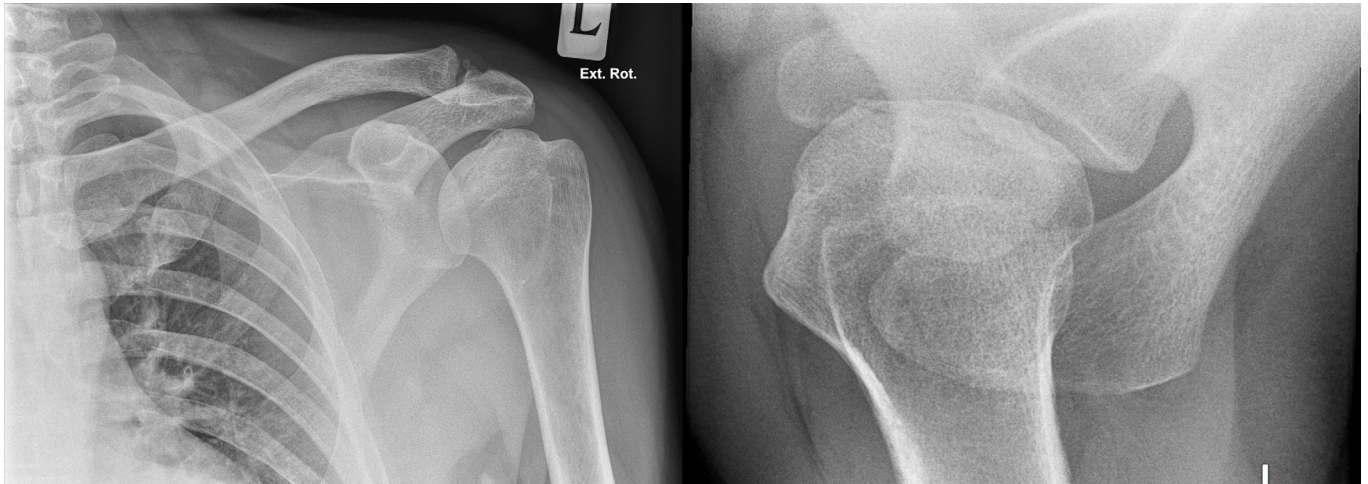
Plain radiographs of the left shoulder, AP (Left) and Trans -axillary views (Right). Subchondral lucency and periarticular sclerosis can be seen as suggestive of AVN.
